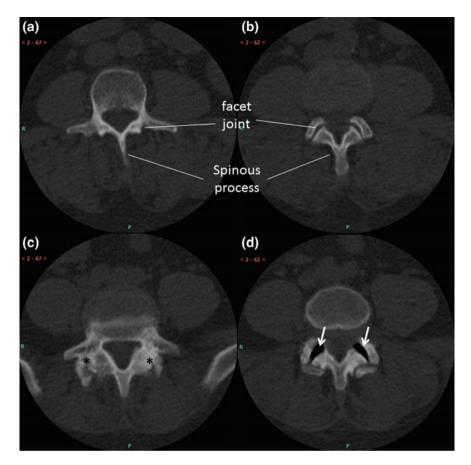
Facet joint osteoarthritis on computed tomography. a, b Axial view of a normal lumbar spine. c, d Axial view of a lumbar spine with facet joint osteoarthritis. Hypertrophy (*asterisks*) and erosions (*arrows*) are common findings in facet joint osteoarthritis
